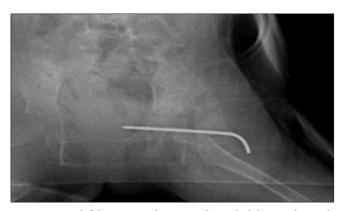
Post left hip open reduction and acetabulplasty radiograph.
